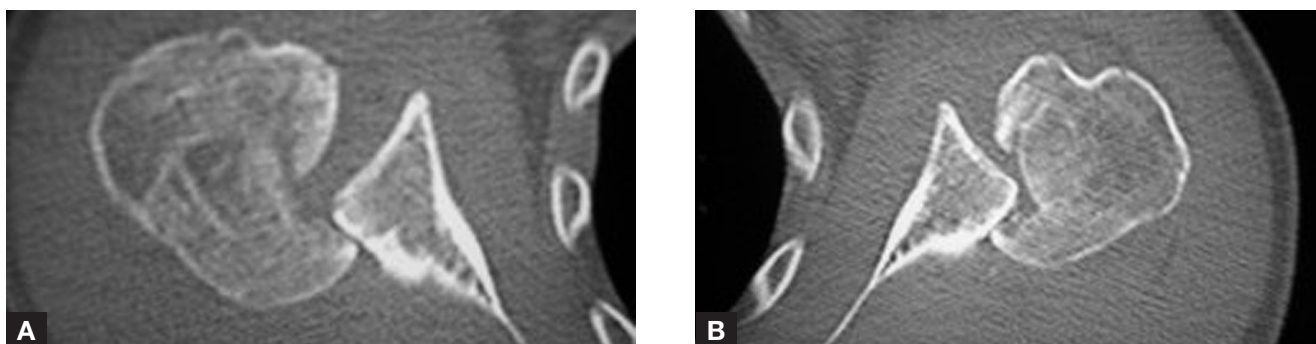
CT scan showing articular impaction fracture of more than 50% of the articular surface in the left (A) and right (B) shoulders.
